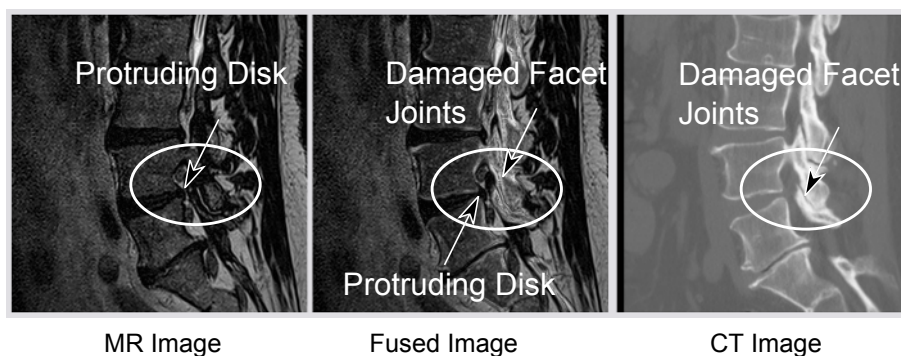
Images of damaged spine, left MR - showing bulging disk, middle - Fused image showing the disk, the spinal cord and the damaged facet joints, right - CT image with damaged facet joints.
